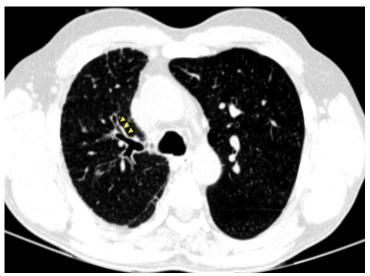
34 year old male with proximal interruption of right pulmonary artery Axial plain CT of the thorax showing mild peribronchial cuffing.
